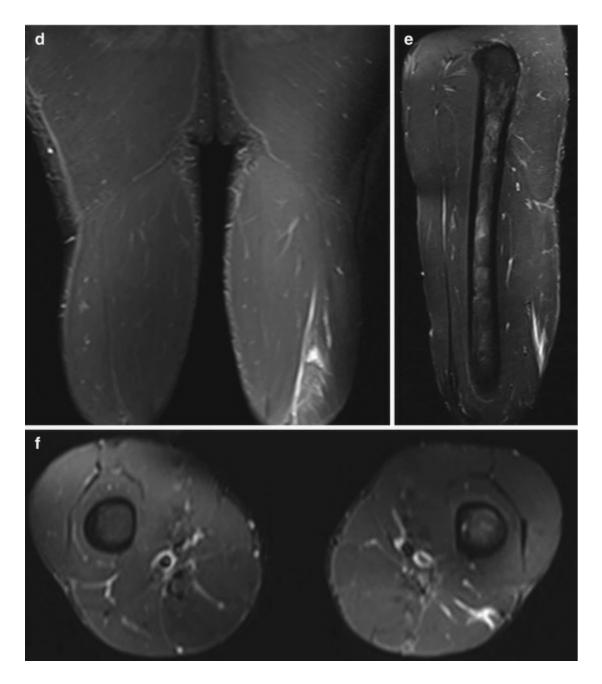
A 33-year-old male professional soccer player with a grade 2 strain of the short head of the biceps femoris. Coronal (a), sagittal (b), and axial (c) STIR MRI show edema and intramuscular hematoma at the short head of the biceps femoris, associated with a small amount of intermuscular fluid. Follow-up STIR MRI (d-f) obtained in the same planes one month after the initial examination demonstrate the reduction of edema and hematoma
